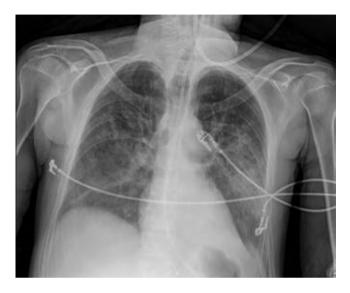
Chest X-Ray at 24 hours after admission compatible with adult respiratory distress due to inhalation syndrome. Source: authors.
